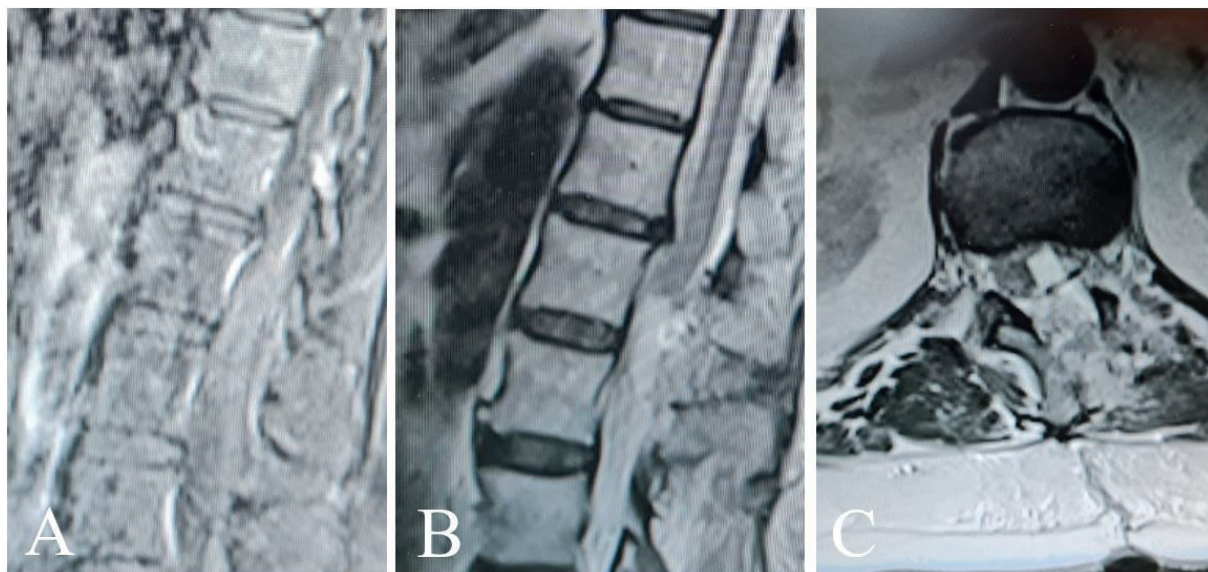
Postoperative MR images of a patient with thoracic schwannoma A. Sagittal Postcontrast T1 B. Sagittal T2 C. Axial T2
